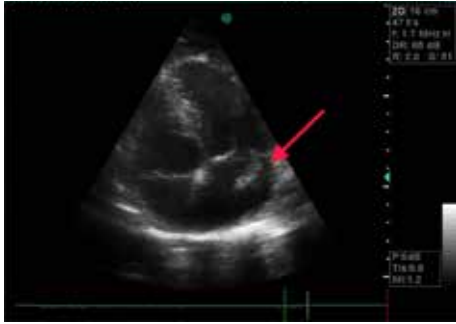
Transthoracic apical four chamber view; arrow indicates vegetation on tricuspid valve.
